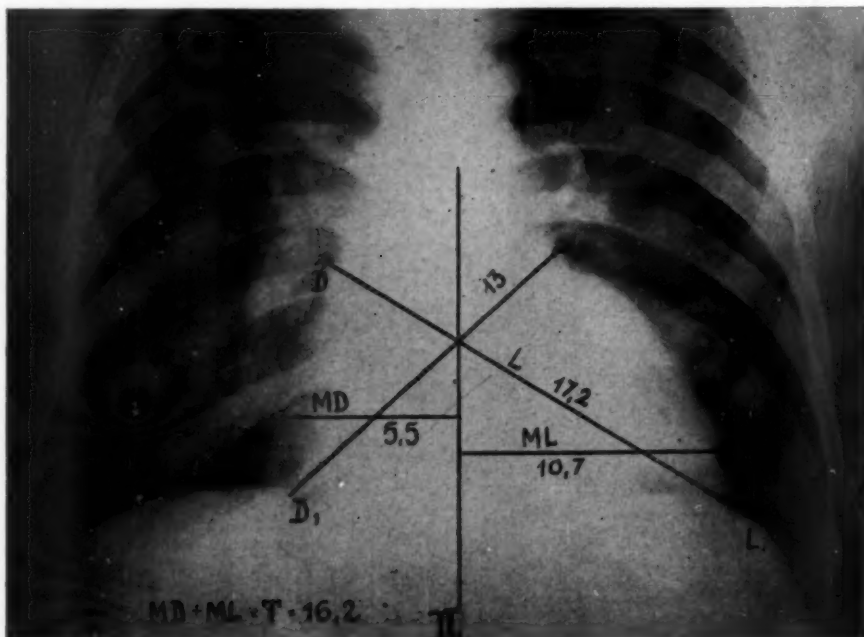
X-ray teleroentgenogram of the heart before operation.
